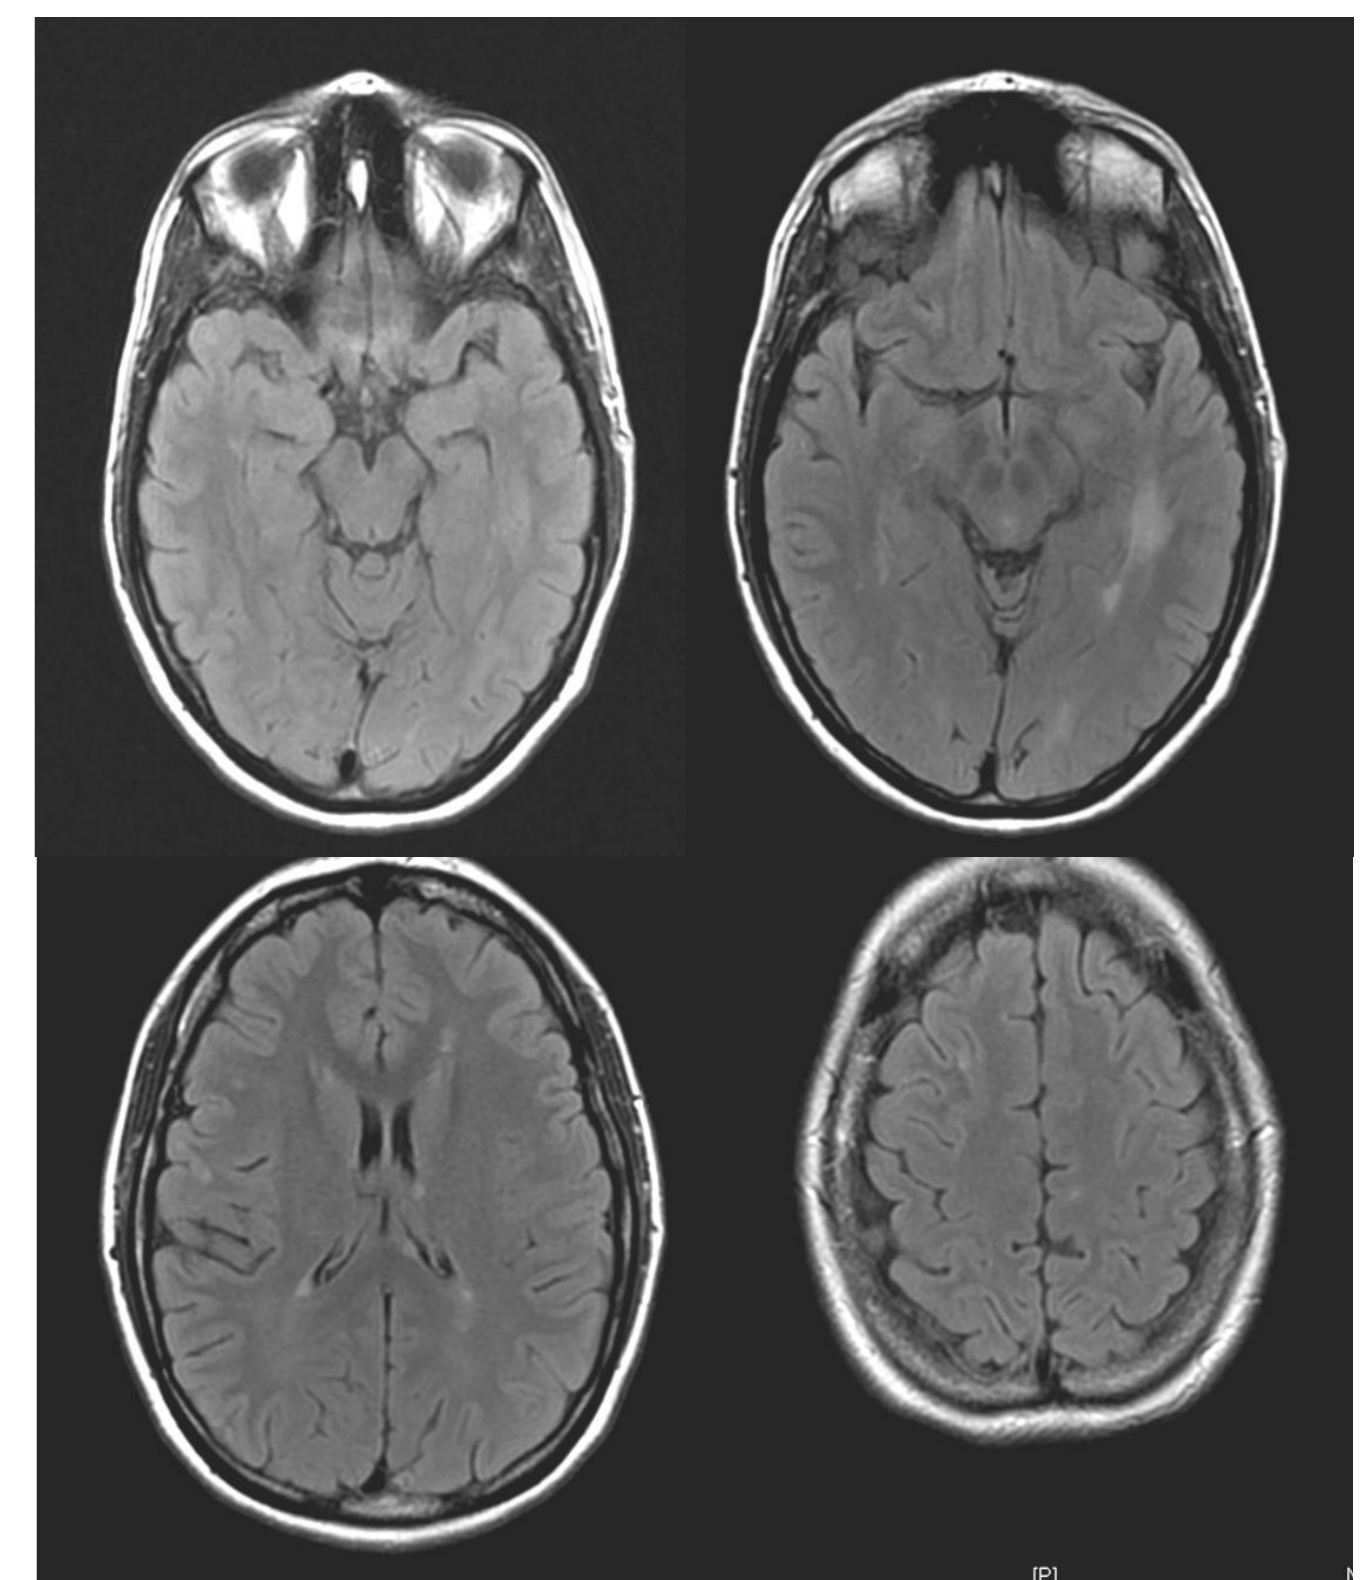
brain MRI: white matter lesions in FLAIR
